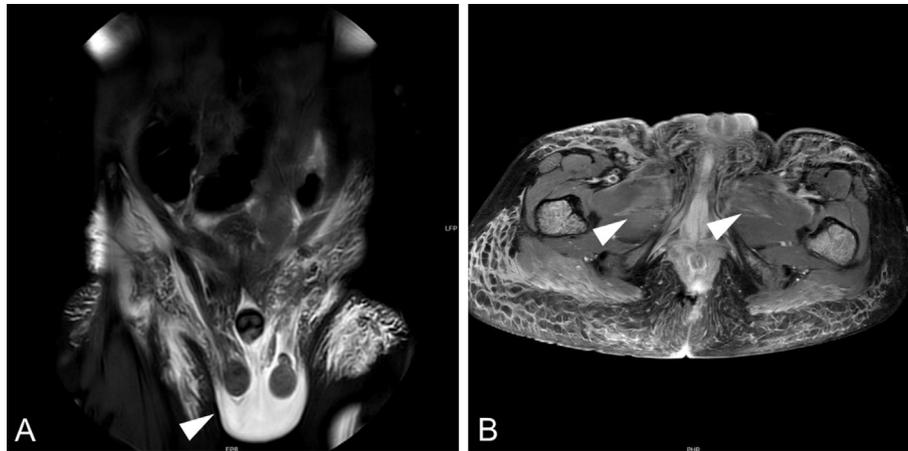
MRI scan of pelvic region. T2 weighted images. Arrow heads indicate oedematous swellings and fluid retention.
